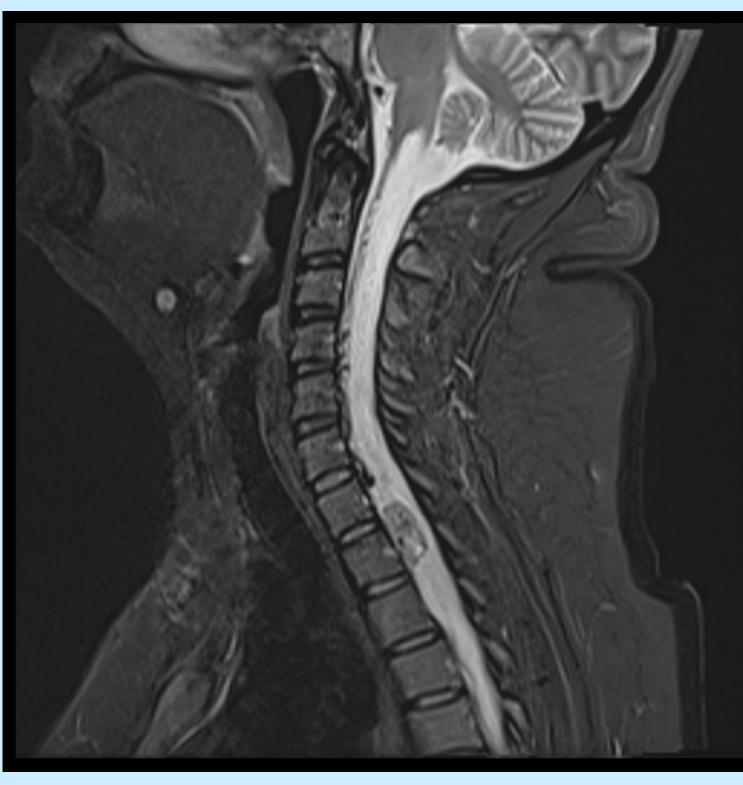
T2-weighted image demonstrating hemangioblastoma at C7-T1.
